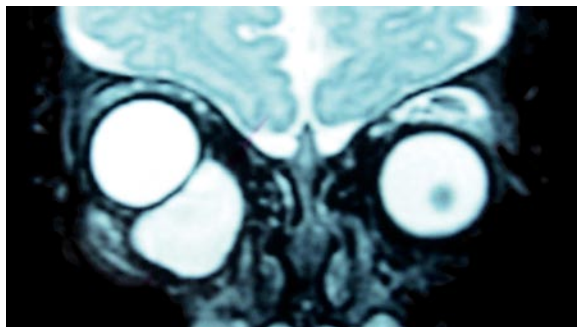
Coronal MRI section demonstrating right microphthalmia with cyst. These are typically inferior to the globe and cause a bulge in the lower lid
